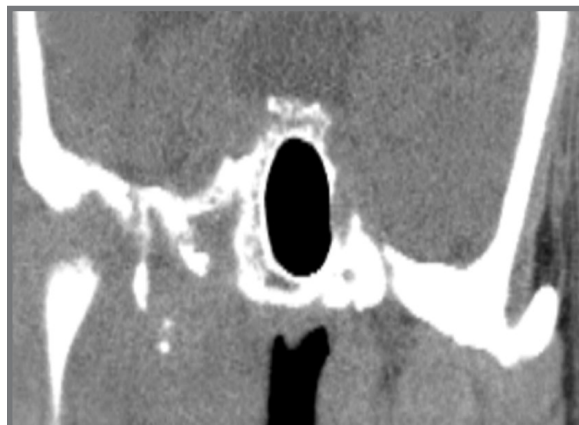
HRCT temporal bone showing erosion of the carotid canal.
